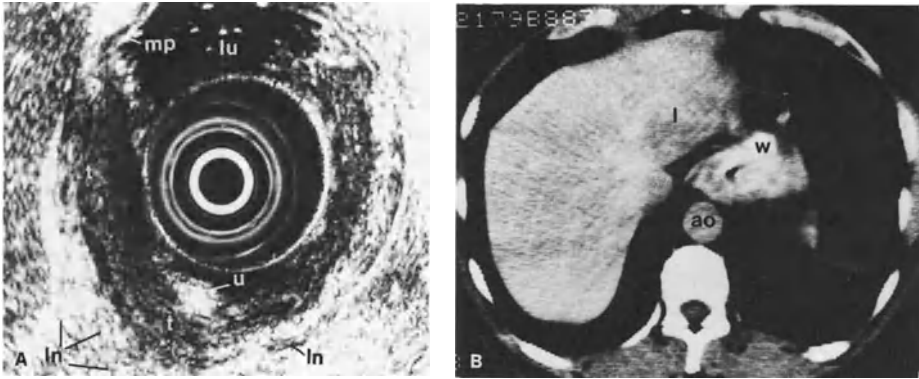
A Endoscopic sonogram showing a hypoechoic tumor (*t*) penetrating into the muscularis propria (*mp*) adjacent to an ulcerative lesion (*u*), with some small adjacent lymph nodes (*ln*) not suggestive of malignancy. *l*, liver; *lu*, lumen. B Corresponding computerized tomography scan, showing thickening of the wall (*w*) adjacent to the liver (*l*) and aorta (*ao*)
